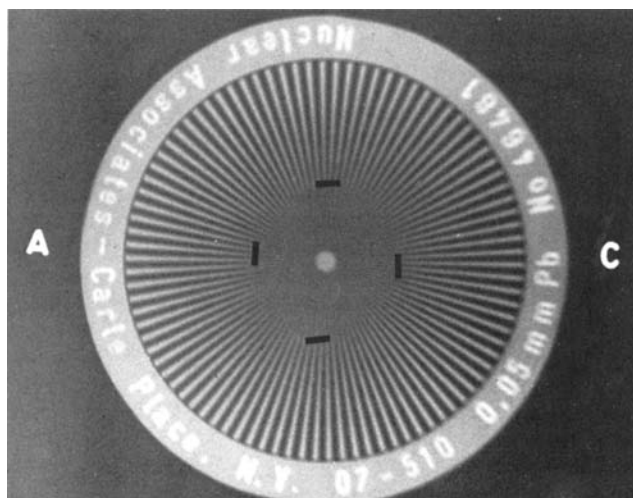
The radiograph of a 2° star pattern used to measure focal spot sizes. The radiograph was taken at 120 kVp and 100 mA with a magnification factor of 2.9. The manufacturer's specified focal spot size was 0.60 mm. The measured focal spot was 0.83 × 0.90 mm.
